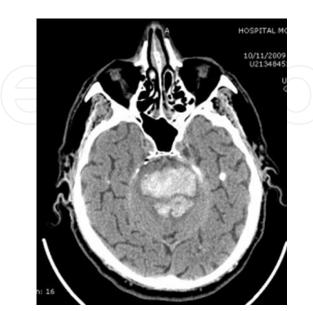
Axial CT demonstrates a large pontine hemorrhage.
